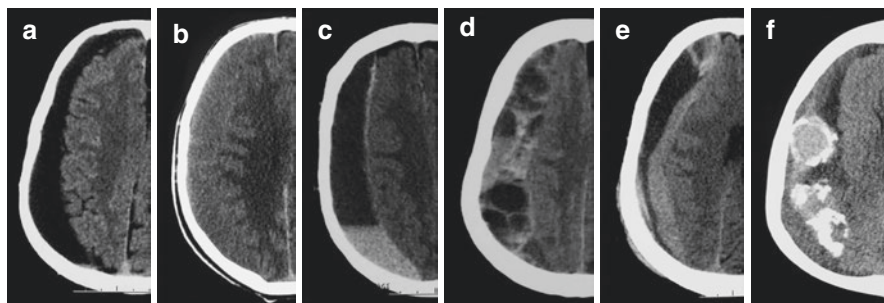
Computed tomography appearance of various types of intracranial chronic subdural hematomas. (a) Low density. (b) Isodensity. (c) Acute on chronic SDH. (d) Mixed density with multilayer loculations. (e) Organized SDH. (f) Calcified/ossified SDH
